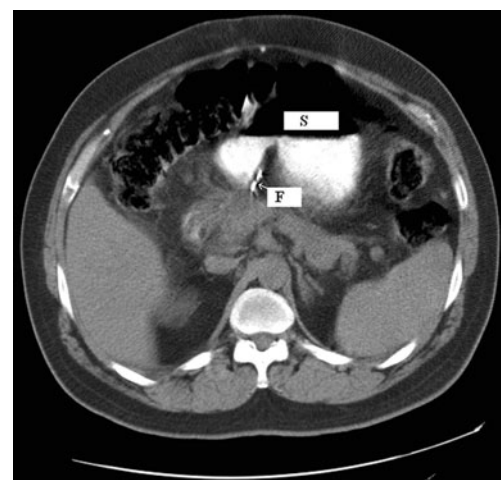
CT scan 1 year after cystogastrostomy. Persistent fistula (F) is appreciated between the stomach (S) and the retroperitoneum.
